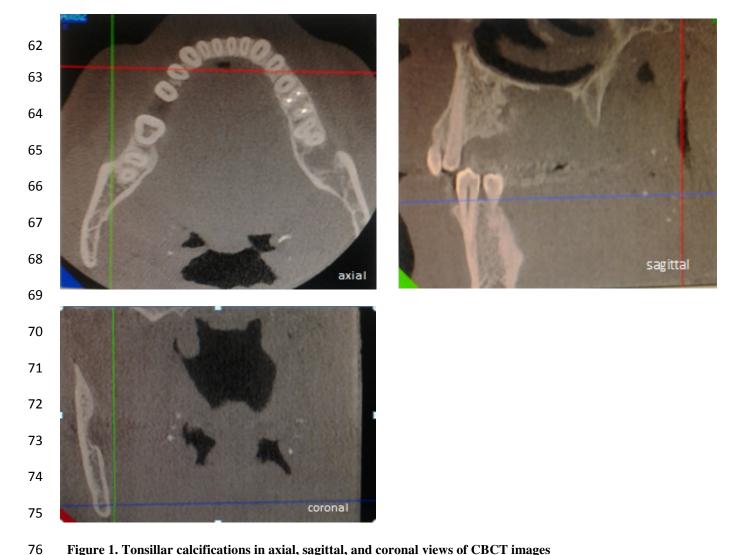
Tonsillar calcifications in axial, sagittal, and coronal views of CBCT images
